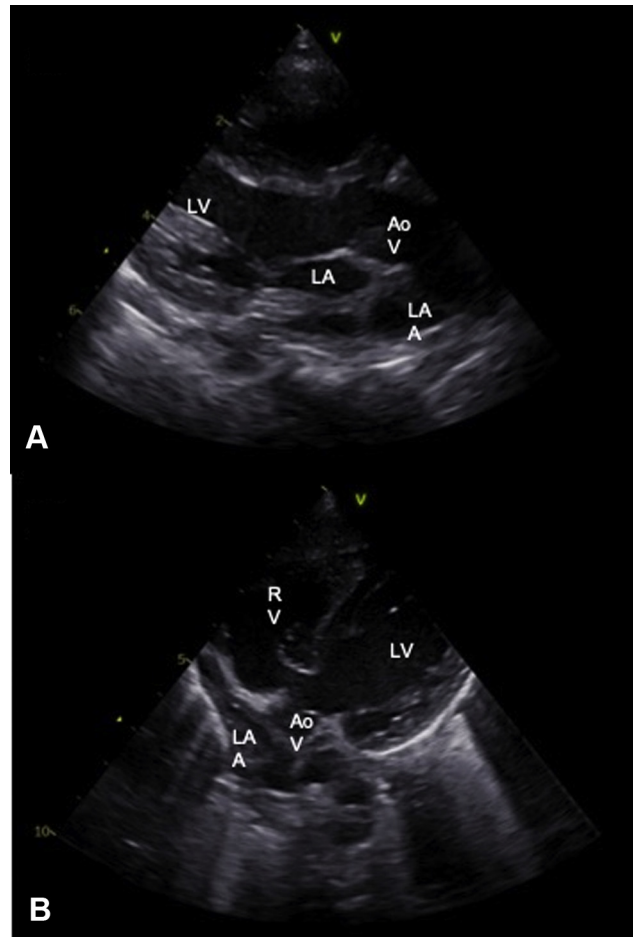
Preoperative transthoracic echocardiography. A, Parasternal long-axis view showing the left atrial appendage (LAA) cranial to the left atrium (LA). B, Tilted 5-chamber view showing the LAA behind the aorta. LV, Left ventricle; AoV, aortic valve.
